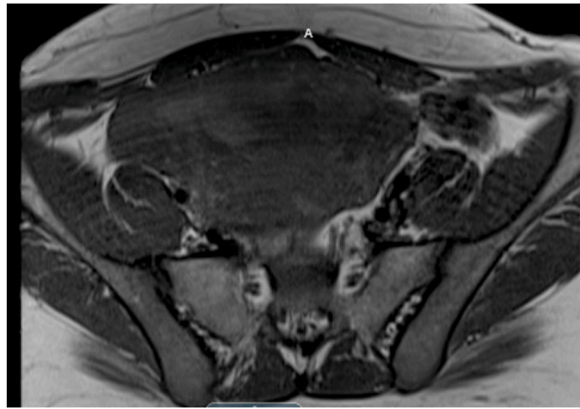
T1 MRI at time of diagnosis.
